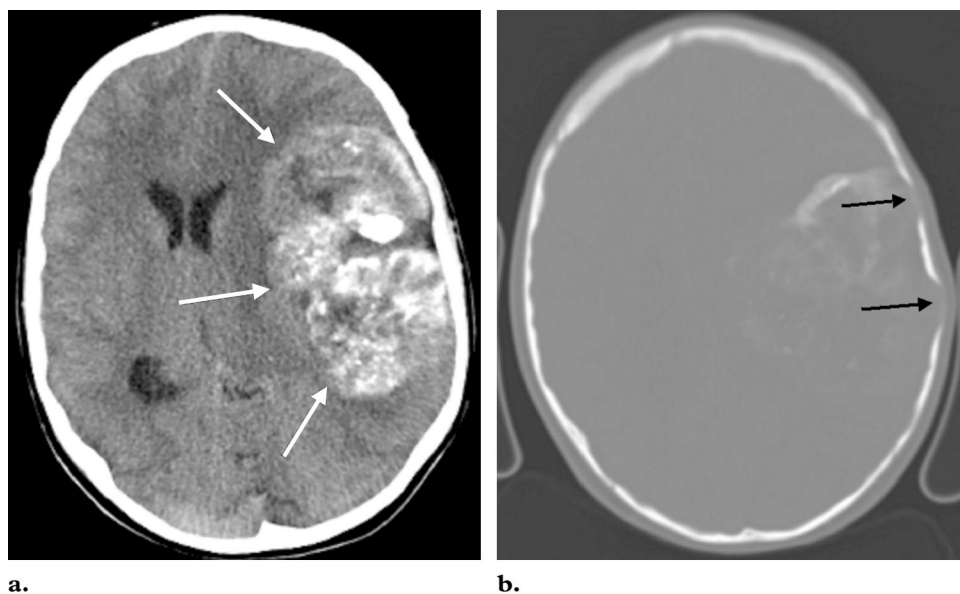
(a) Axial unenhanced CT scan of the brain shows a large (9.5×6 cm) space-occupying lesion in the left cerebral hemisphere (arrows) with mass effect and large internal calcifications. (b) Axial unenhanced CT scan of the brain (bone window) shows scalloping of the internal cortex of the parietal bone (arrows) and the calcifications in the tumor.
